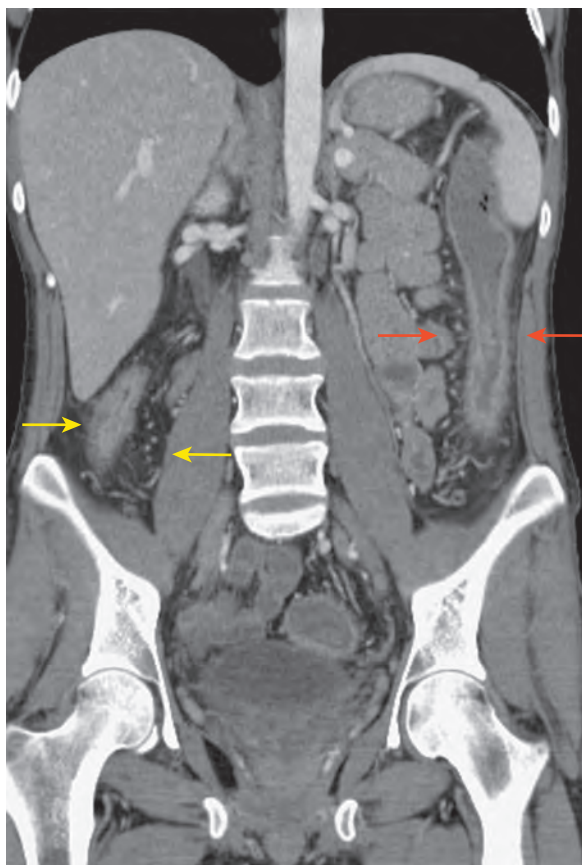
Crohn's disease: acute disease on CT. Coronal reformatted image shows mural thickening of the ascending (yellow arrows) and descending (red arrows) colon, with engorgement of the vasa rectae indicating active, acute disease.
